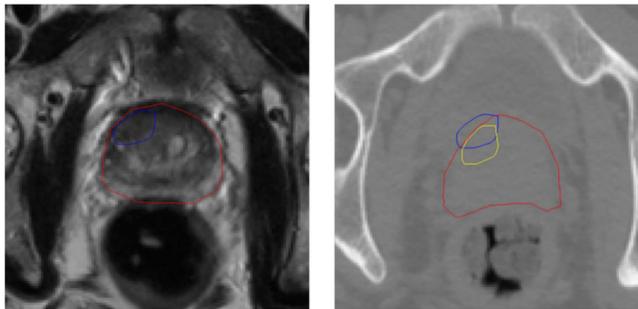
MR image (left) and CT image (right) of a prostate cancer patient acquired at different times. The red contour shows the outline of the prostate gland, the blue contour shows the position of the focal lesion as identified from the MR image, and the yellow contour shows the suspected position of the focal lesion on the CT image¹.
